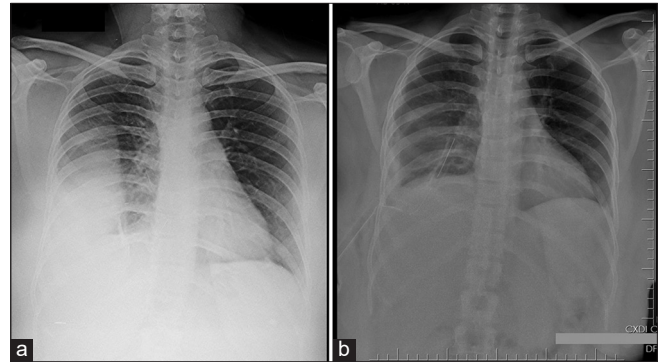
Chest X-ray showing pleural fluid drainage; (a) before and (b) after drainage
